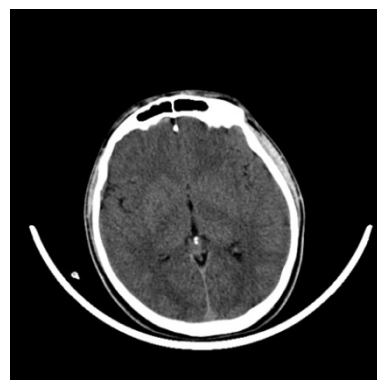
Bilateral basal ganglia hyperdensity on computed tomography (CT) scans
